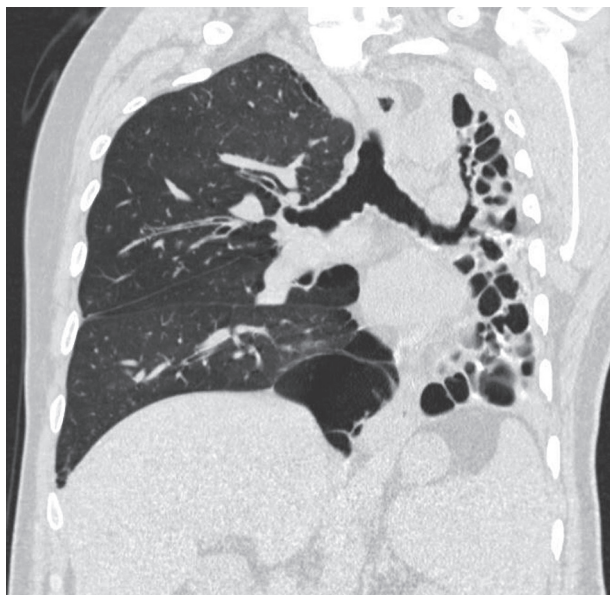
Coronal computed tomography lung window images showing cystic bronchiectasis with collapse of the entire left lung as a sequela of tuberculosis
